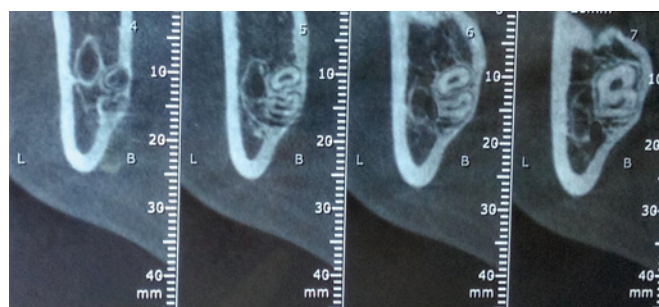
CBCT sections showing the contact of the right lower third molar roots with mandibular canal
